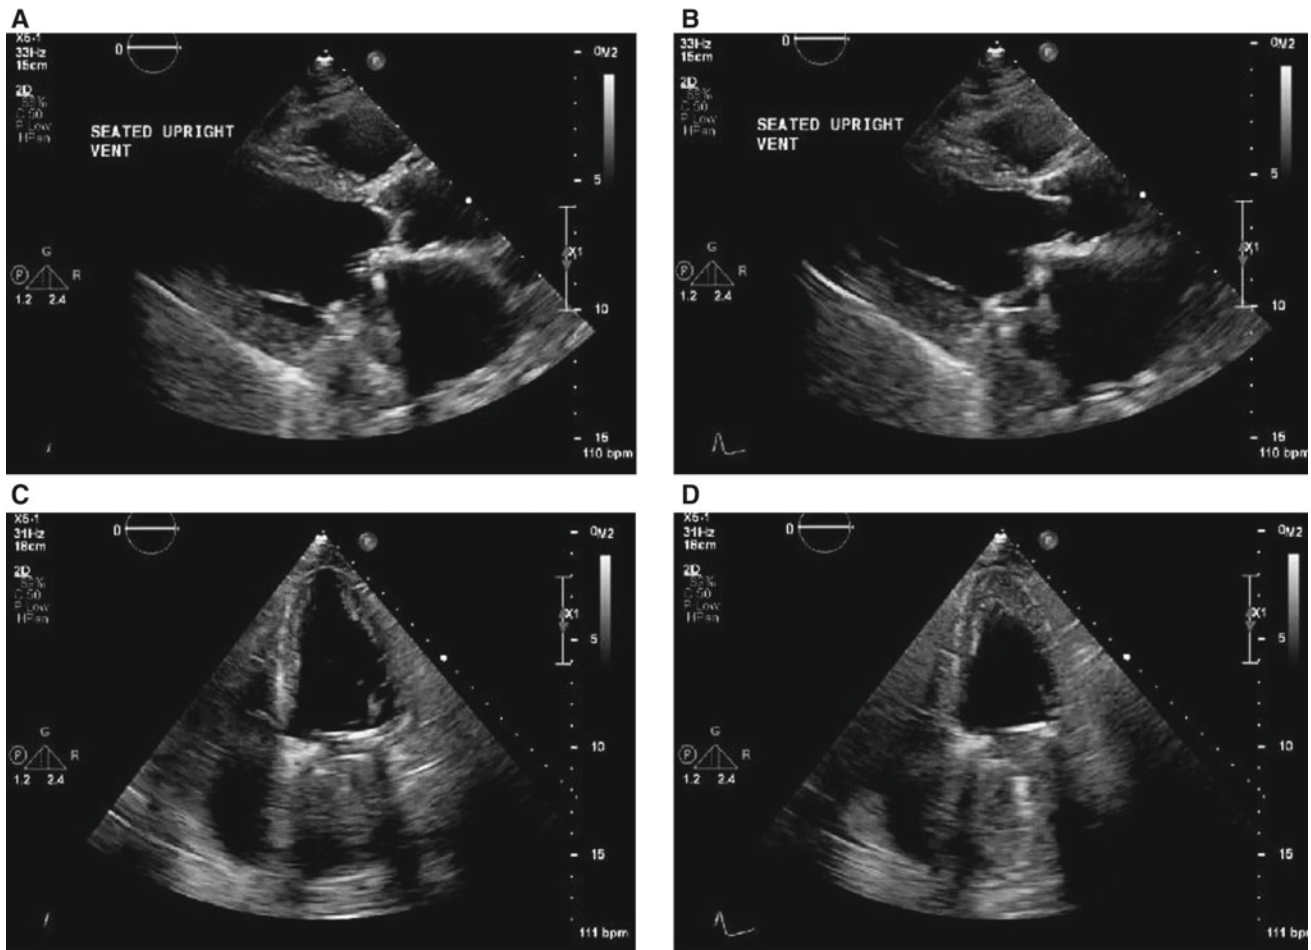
Diastolic (A, C) and systolic (B, D) frames from parasternal long axis (top) and apical four-chamber (bottom) echocardiographic studies. There is moderate global hypokinesis of the left ventricle. Shadowing from the mitral valve prosthesis is seen
